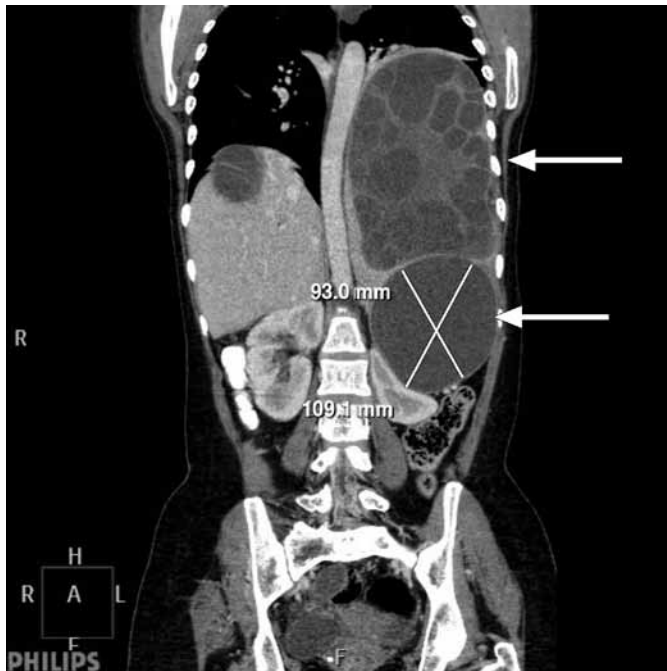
Abdominal coronal CT image reveals cystic lesions in the chest and below the diaphragm and a large cyst in the spleen (measuring 93mm x 109mm) pressing the left kidney (arrow).
